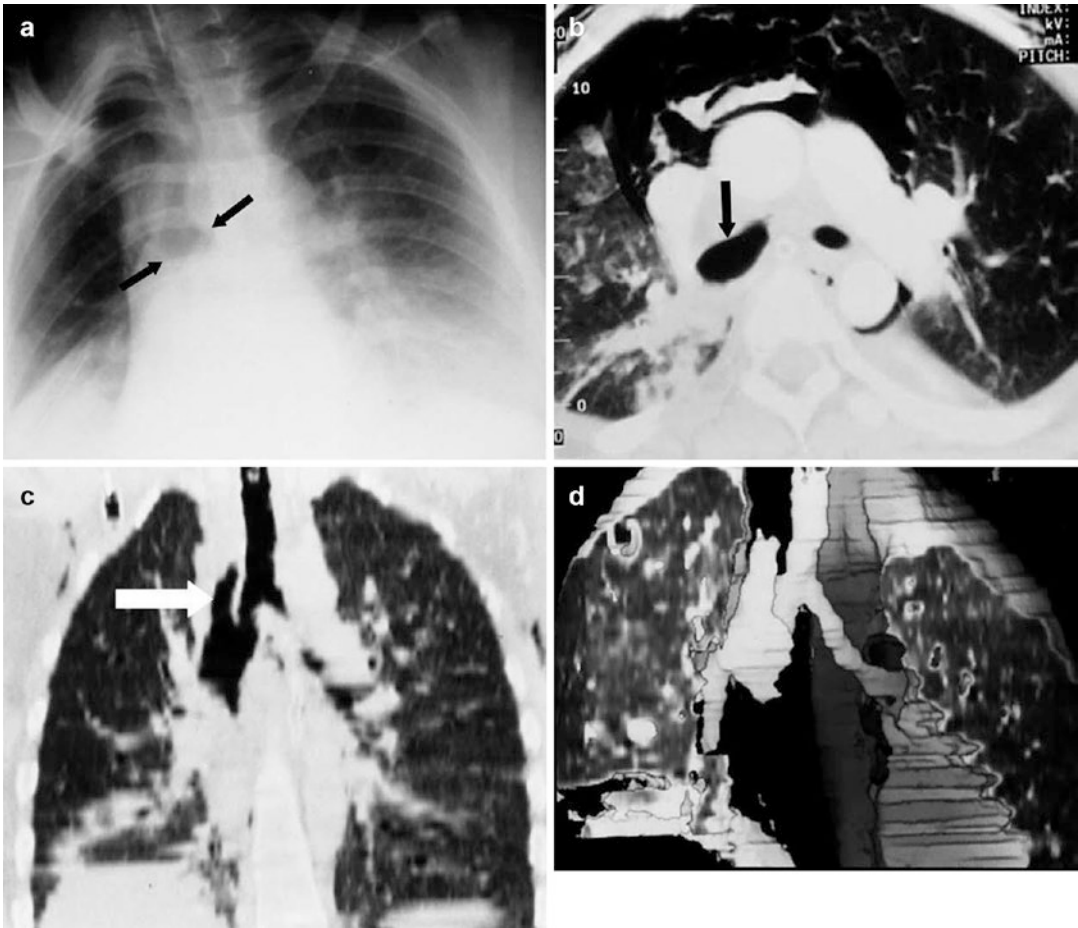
Blunt bronchial injury after motor vehicle crush. (a) Supine chest radiograph shows enlargement of the right main bronchus (arrows). (b) Axial CT scan confirms the enlargement of the right main bronchus (arrow). (c) Frontal MIP CT
